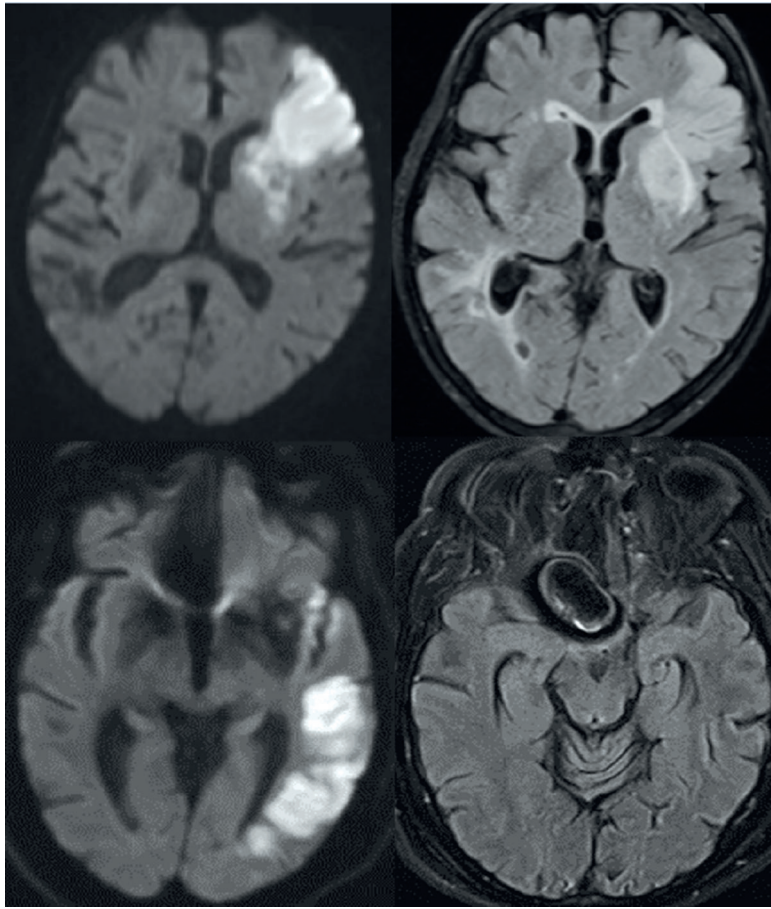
Comparisons of DWI and T2 FLAIR images in acute and hyperacute ischaemic strokes without large vessel occlusion. Top: DWI hyperintensity in left frontal region (left), with corresponding T2 FLAIR hyperintensity (right), showing acute ischaemic stroke. Bottom: DWI hyperintensity in left temporal region (left) without corresponding T2 FLAIR hyperintensity (right) from hyperacute MRI protocol. The patient with the bottom images would be considered a potential candidate for intravenous thrombolysis based on the MRI. DWI=diffusion weighted imaging; FLAIR=fluid attenuated inversion recovery; MRI=magnetic resonance imaging
